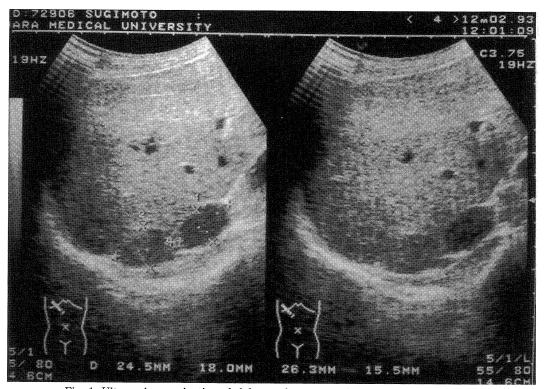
Ultrasonic examination of abdomen shows an oval hypoechoic tumor  $(26.3 \times 15.5 \text{ mm})$  in the upper-portion of the rigth adrenal gland and another tumor  $(24.5 \times 18.0 \text{ mm})$  was found beneath the liver like enclosed in it.
